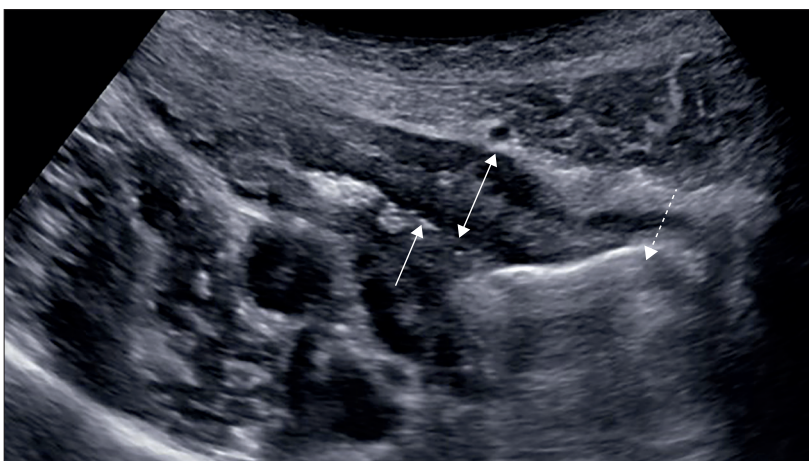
Longitudinal view of terminal ileal stricture with bowel wall thickness at 9.3 mm (double-headed solid arrow), luminal apposition at 1.3 mm (solid arrow), and pre-stenotic dilation (dashed arrow). Echogenic mesenteric inflammatory fat is present around the stricture with loss of bowel wall layer stratification. Treatment response of strictures is defined as reduction in stricture length, bowel wall thickening, luminal narrowing, pre-stenotic dilation, mesenteric inflammatory fat, mural or peri-enteric hyperaemia as measured by colour Doppler signal, comb sign, motility abnormalities, and improved loss of bowel wall layer stratification.
